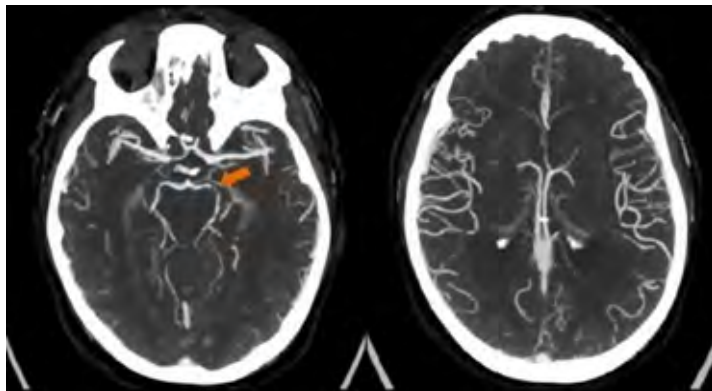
CT angiography of the cervical and intracranial vessels with a 50% reduction in contrast dose in a patient with impaired renal function showing high-grade stenosis of the left posterior cerebral artery (arrow).
